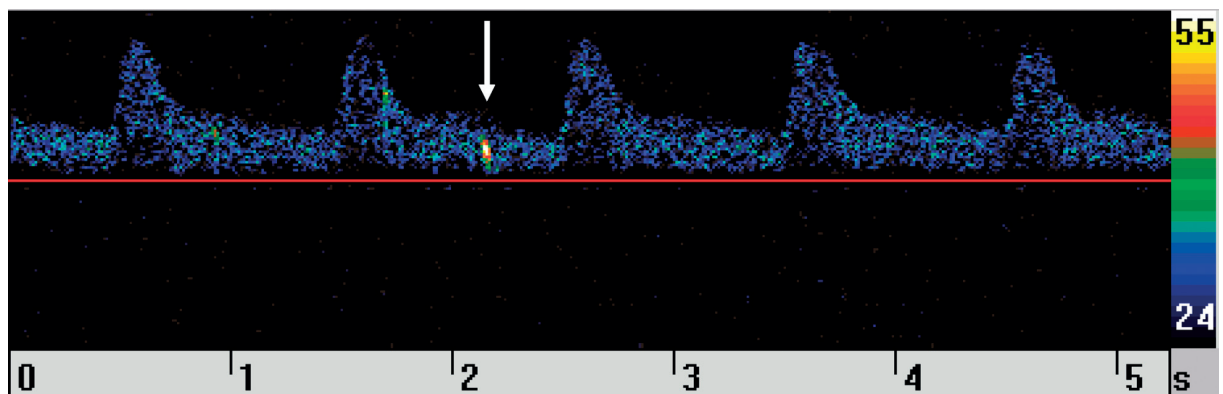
Middle cerebral artery Doppler frequency spectrum of a patient with an 80% internal carotid artery stenosis. The microembolic signal was accompanied by a characteristic chirping sound.
